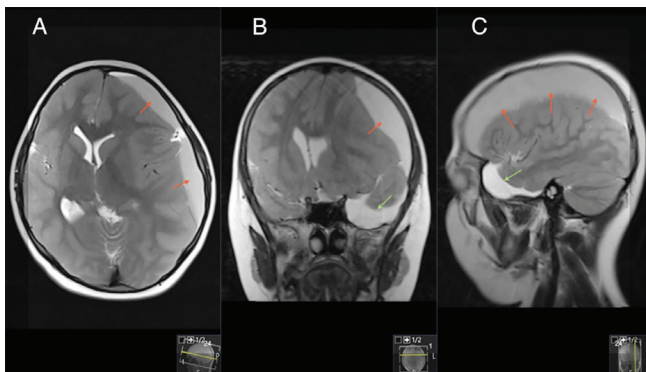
Preoperative magnetic resonance imaging in the axial (A), coronal (B), and sagittal (C) planes.
